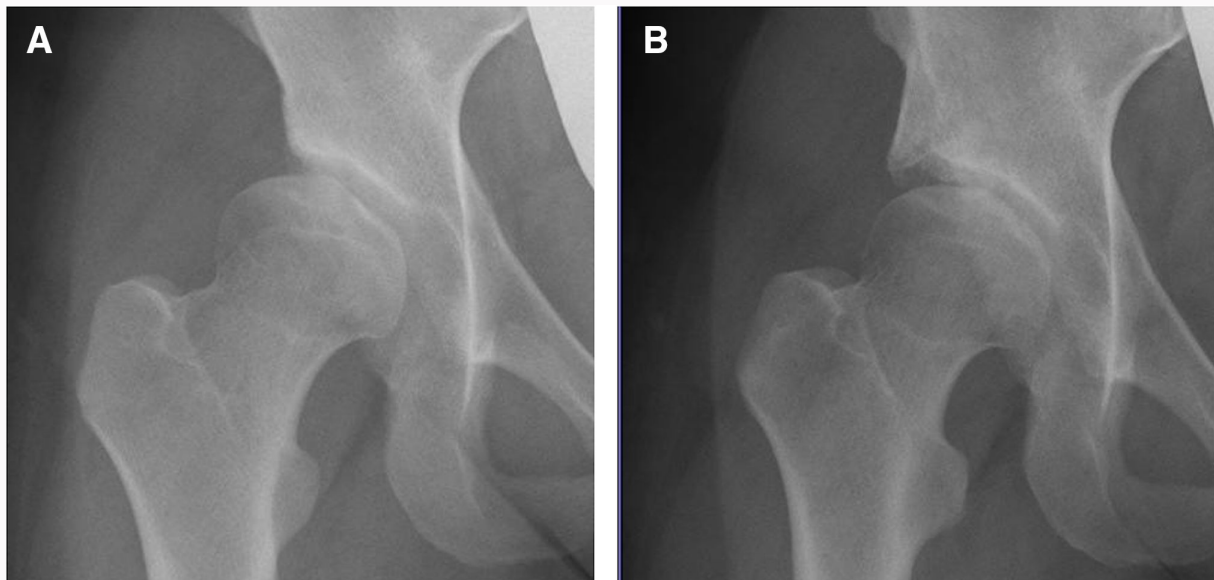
Radiographs of a 23-year-old female who had undergone a modified Spitzzy shelf acetabuloplasty on the right hip: a) preoperatively, osteoarthritis Tönnis grade 0, a lateral centre-edge angle of 9° (Merle d'Aubigné clinical score, 14 points), and b) at ten years postoperatively, no osteoarthritis changes, a lateral centre-edge angle of 37° (Merle d'Aubigné clinical score, 18 points).
